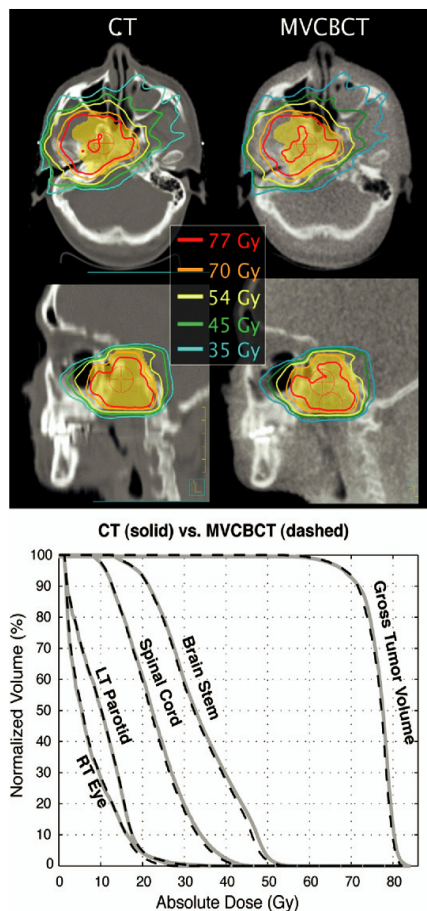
Dose calculation on patient treated for recurrent nasopharyngeal carcinoma with intensity-modulated radiotherapy. No weight loss or anatomy deformation observed between CT and megavoltage cone-beam CT (MVCBCT). (Above) Isodose lines at treatment isocenter planes on conventional CT and MVCBCT. (Below) Good qualitative agreement observed with dose–volume histograms obtained from dose calculations performed using CT (solid lines) and MVCBCT (dashed lines).
